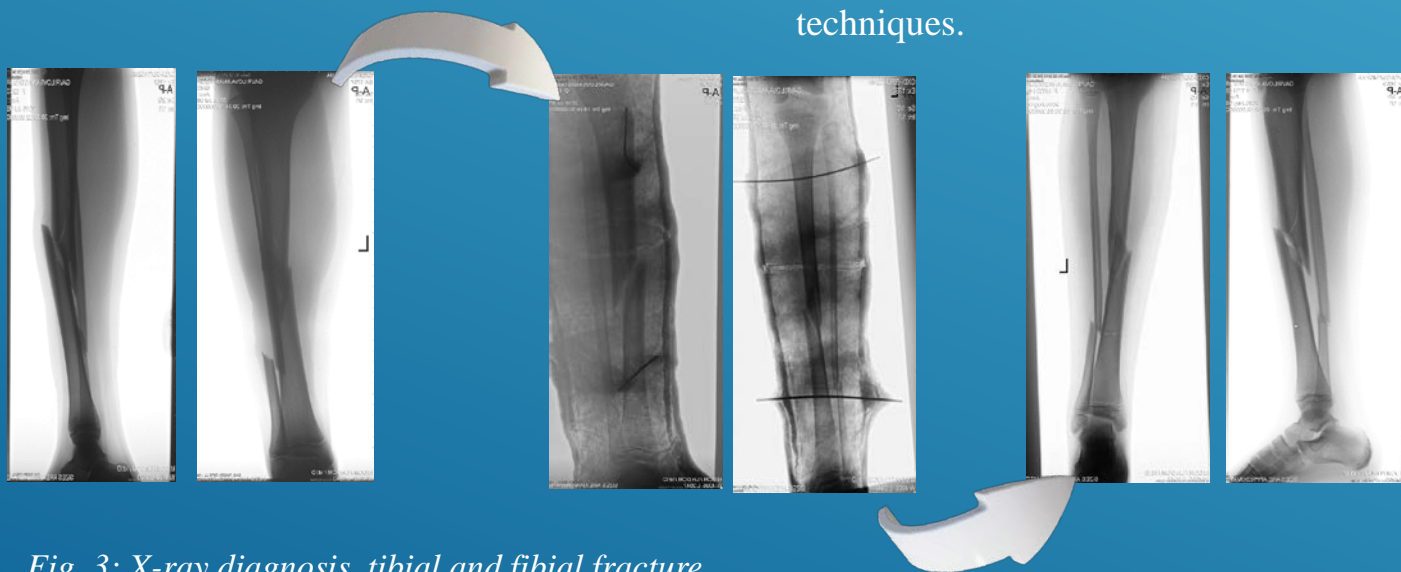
X-ray diagnosis, tibial and fibial fracture
